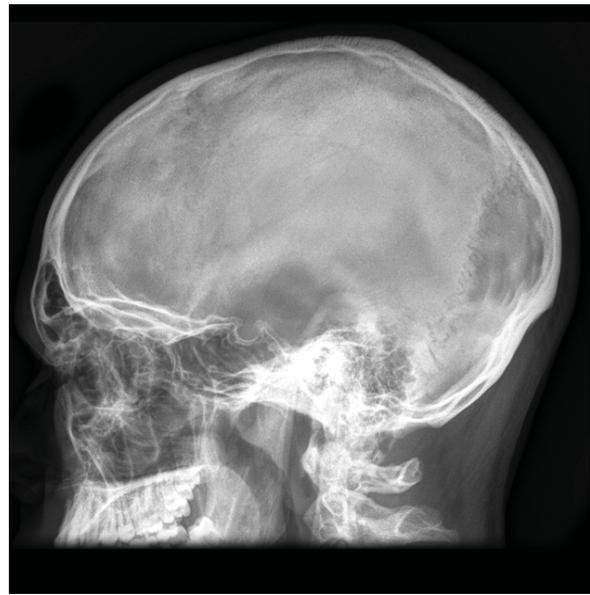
Normal skull radiograph.
